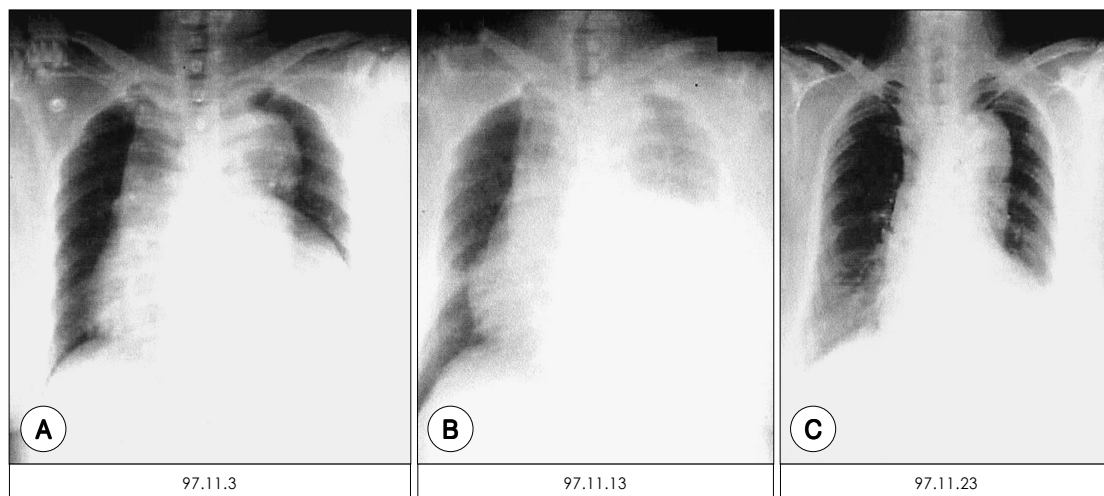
Serial chest X-ray films showing dramatic decrease of mediastinal widening and left pleural effusion in a patient with proximal aortic intramural hematoma treated medically.
